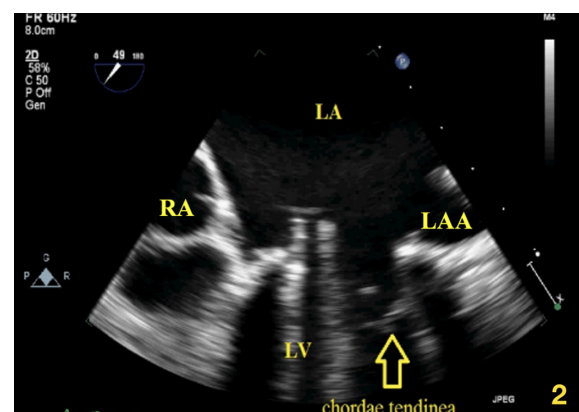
Transesophageal echocardiography images indicate residual chordae causes restraining the closure of mitral valve leaflet. LA, left atrium; LV, left ventricle; RA, right atrium.
